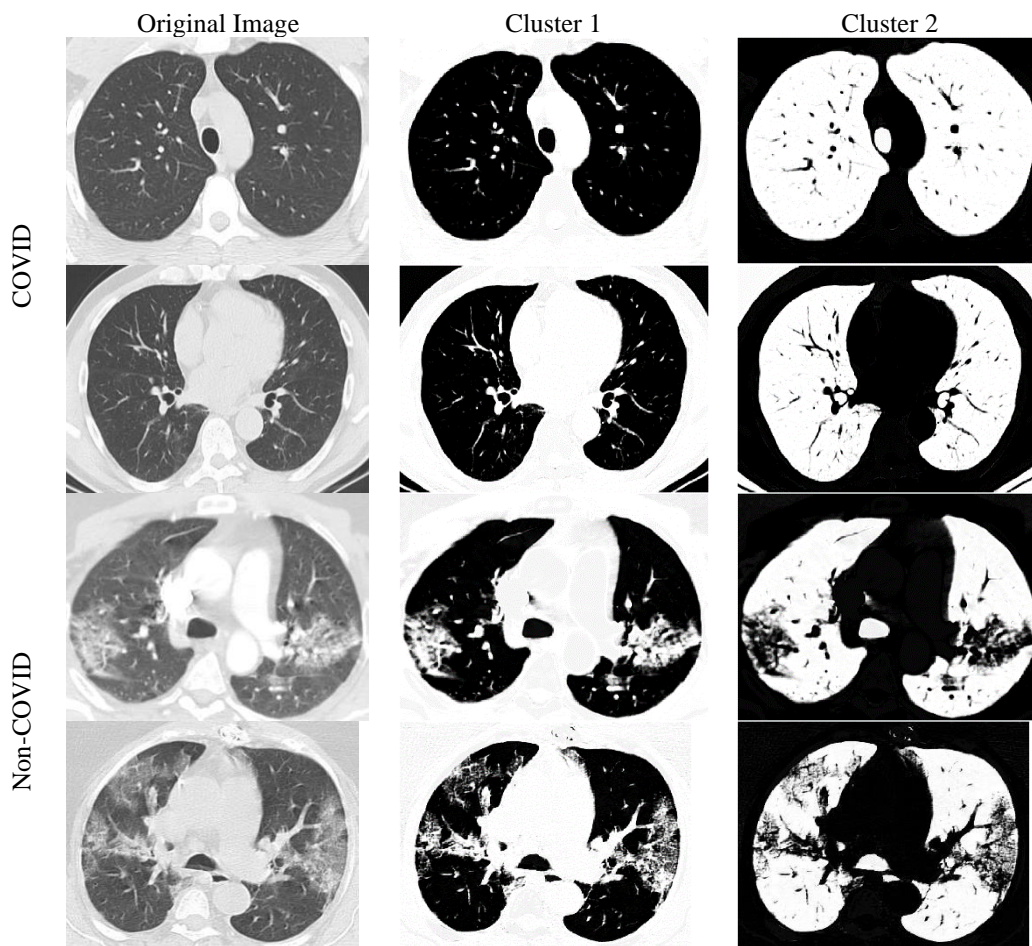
Segmented Sample CT images with FCM method
